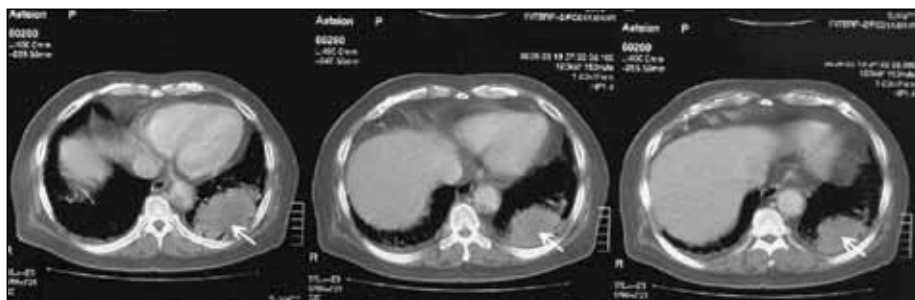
CT scan of the chest showing a solid, well defined, rounded lesion in the left lung posteriorly
